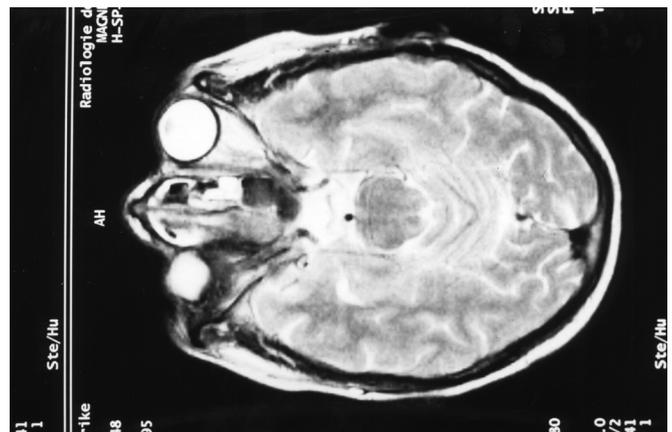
Patterns of generalization: Evolution of vasculitis and persistence of granulomas or slow progression of granulomatous inflammation. Biopsy-proven granulomatous inflammation of the respiratory tract, arthralgia, night sweats, weight loss, episcleritis, purpura and c-ANCA were seen at the initial manifestation more than 10 years ago –retrospectively not permitting a clear-cut delimitation of a biphasic course. Recurrent subglottic stenosis and progressive, destructive, therapy-resistant orbital granuloma, predominantly of the right eye, complicated the course for the next 3 years. Three relapses, confined to the nasal cavity, sinus, inner ear and lung with newly developed nodules, have occurred since. Magnetic resonance images of the head disclosed non-homogenous enhancement of intra-orbital masses encasing the optic nerve and infiltrating the intra-orbital muscles, and intense uptake of thickened maxillary sinus mucosa after contrast administration, suggestive of a granulomatous inflammation, as seen on this image.
